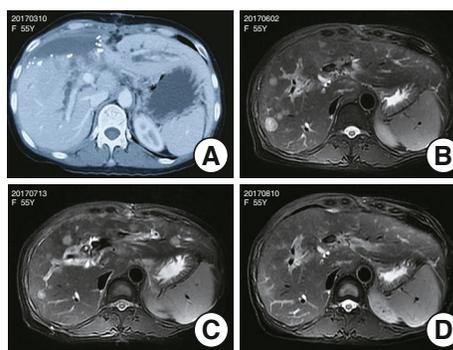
Patient's CT and MRI Pictures
